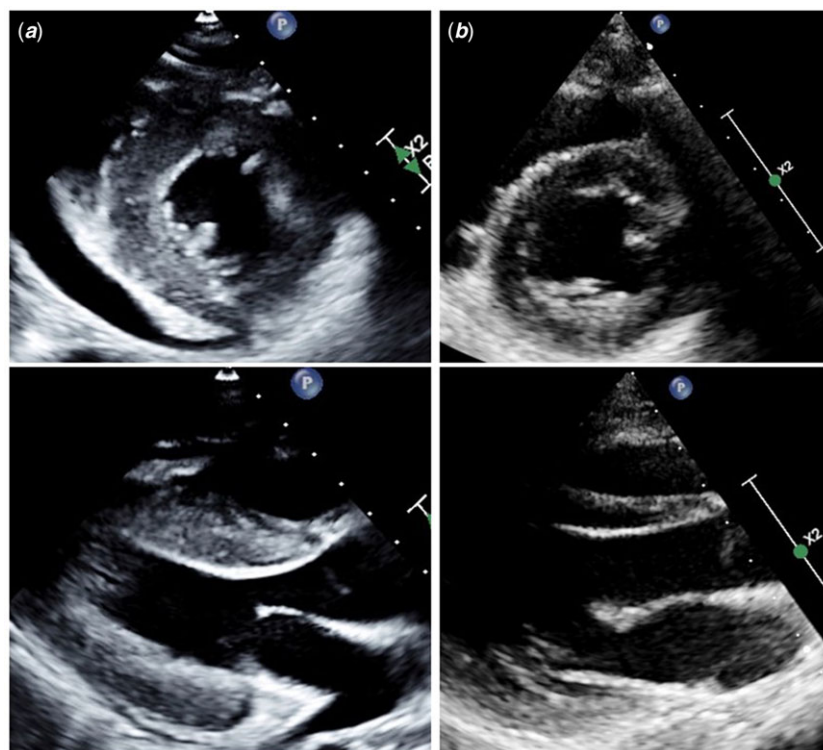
Transthoracic echocardiogram images demonstrating concentric left ventricular hypertrophy on admission (a) with complete resolution at the 1-month follow-up visit (b).
